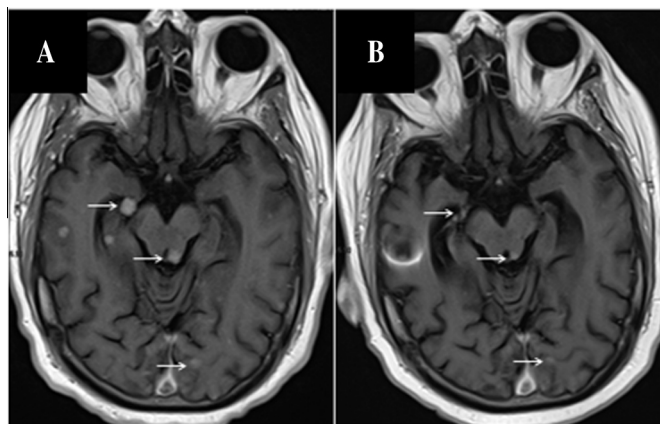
Regression of central nervous system metastases on ceritinib therapy (Patient 1). Contrast-enhanced axial T1-weighted MRI in a patient with brain parenchymal and leptomeningeal metastases (arrows) before (A) and 4 months after (B) the initiation of therapy.
